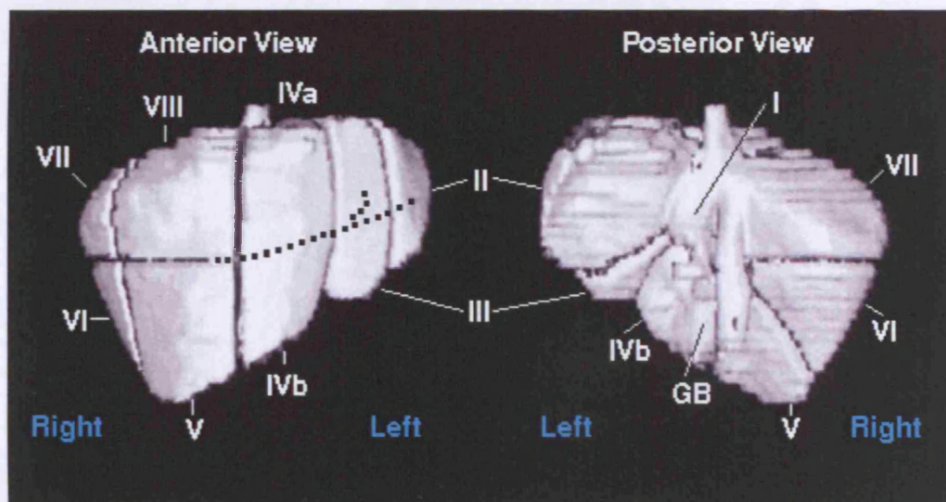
MRI images of the Couinaud liver segments
